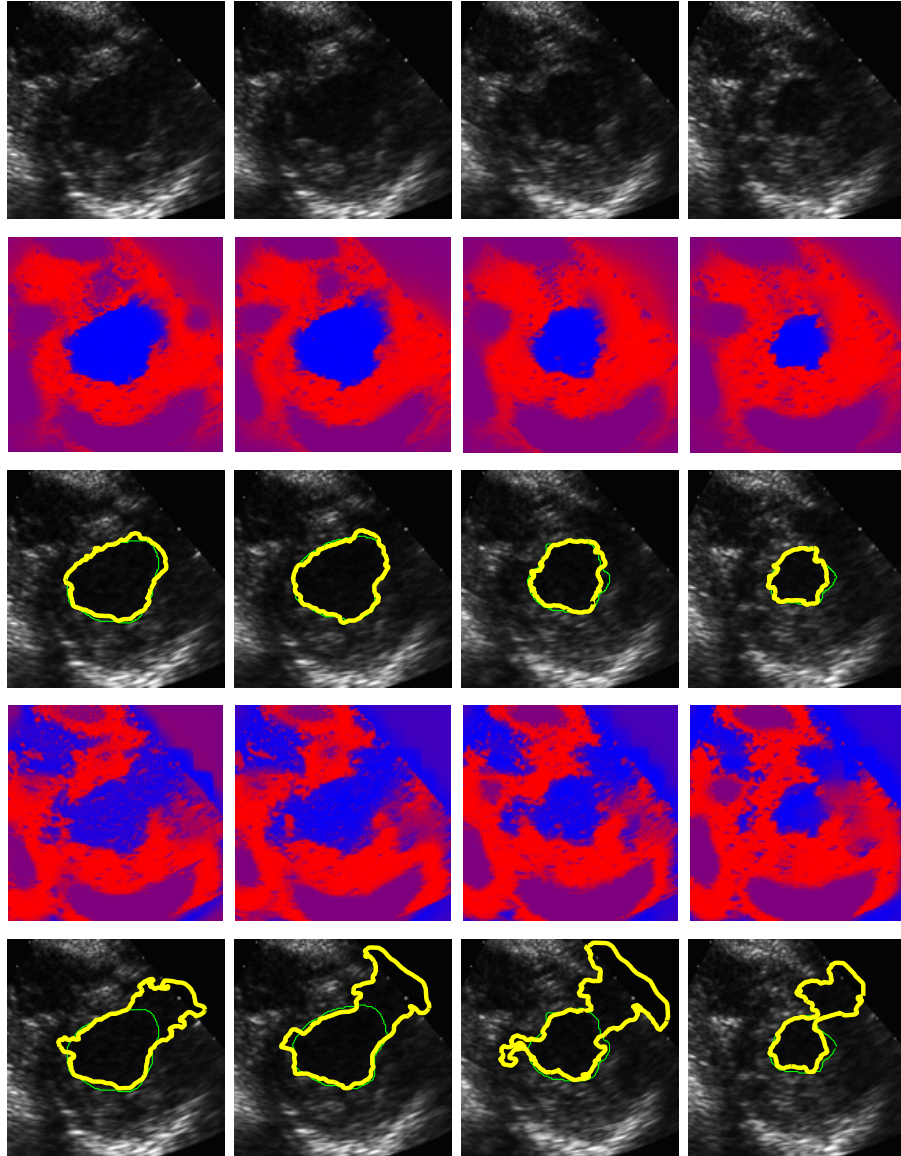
The segmentation of a sequence of echocardiographic images. First row: four frames in the sequence. Second row: the posterior probability map. Blue indicates the ventricular cavity, and red indicates the myocardium. Third row: the results of segmentation: algorithm (yellow) and manual (green). Fourth row: the posterior probability by a spatially homogenous model. Fifth row: segmentation using the spatially homogenous model.
